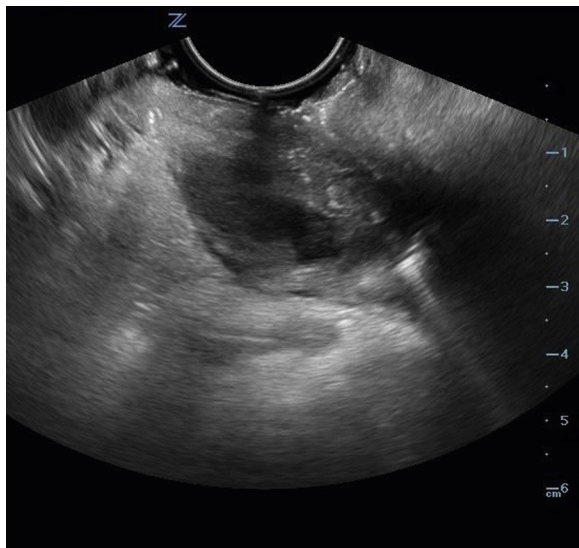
Intraoral ultrasound with an endocavitary probe demonstrating a hypoechoic collection consistent with a peritonsillar abscess. (Image courtesy of Dr. Lindsay Reardon.)
